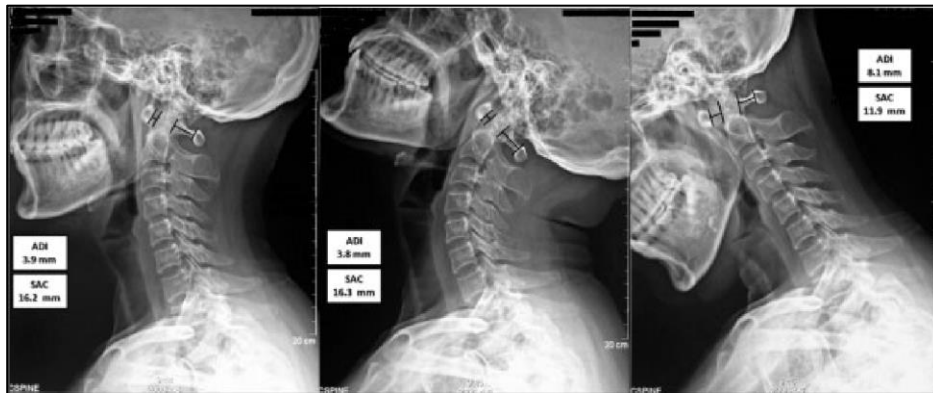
Neutral (left), extension (center), and flexion (right) lateral X-rays showing the atlantodental interval (ADI) anterior to the odontoid process and the space available for spinal cord posteriorly. The ADI is above the average for adults of 3 mm and is slightly reduced in extension, but severely increased in flexion. This patient's space available for spinal cord (SAC) reducing to below 14 mm indicates risk of paralysis. Image from Yang *et al.* 2014.
